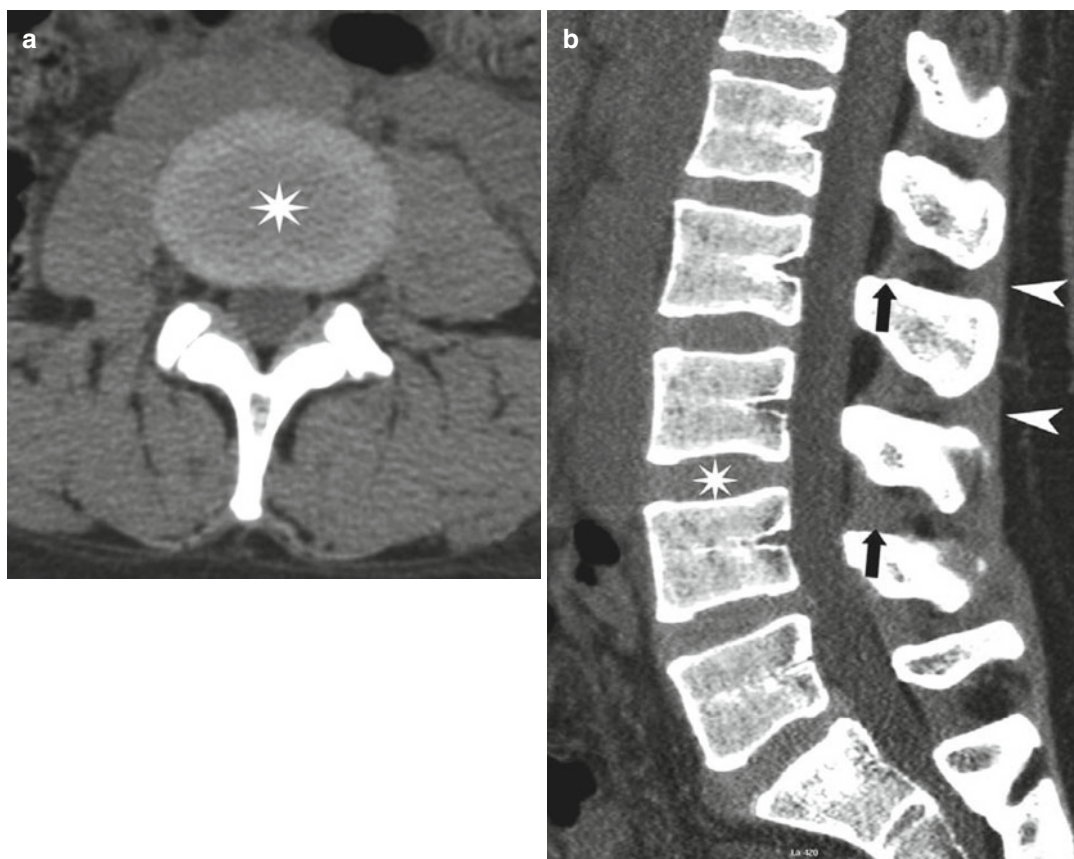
Lumbar spine, CT examination with soft tissue window. (a) Axial section. (b) MPR sagittal reconstruction. The *star* shows L3–L4 intervertebral disc. The interspinous
